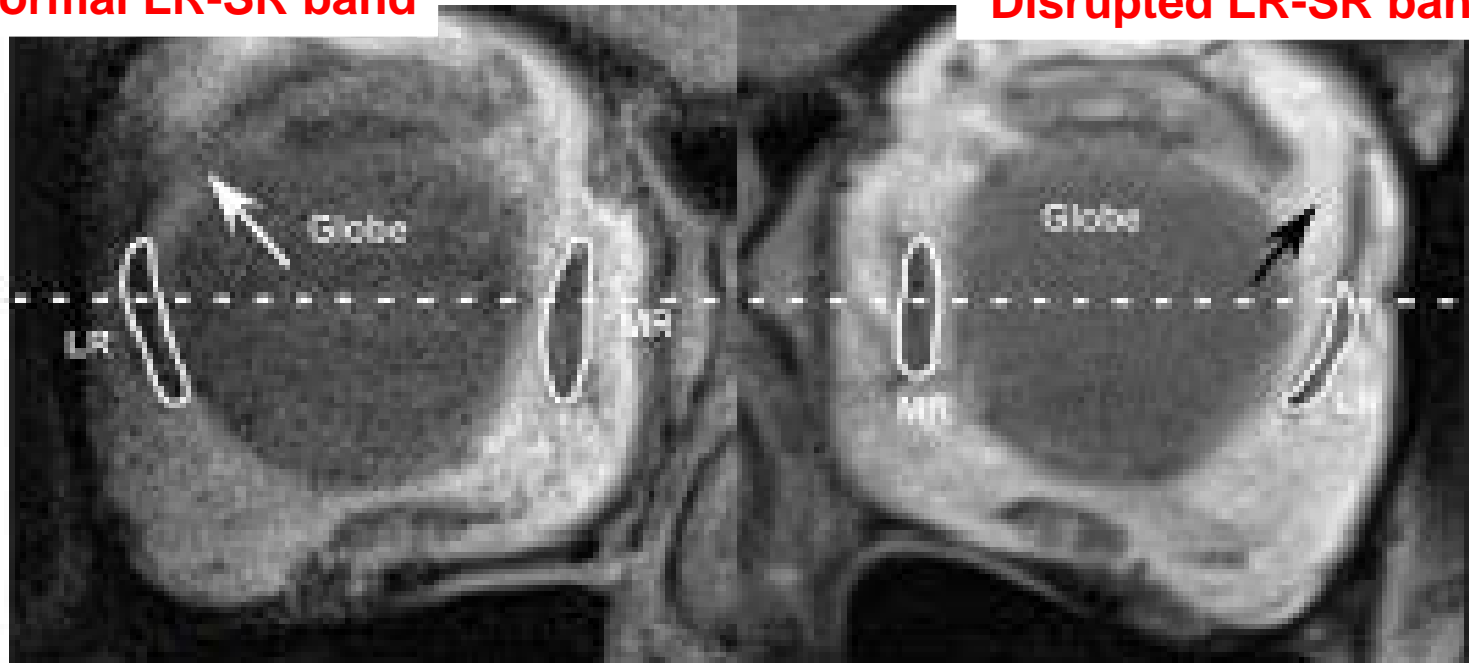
Coronal magnetic resonance imaging near the equator of the globe in an elderly patient with age-related divergence insufficiency esotropia shows an intact lateral rectus-superior rectus band in the right orbit (white arrow) with a normal lateral rectus pulley position and a dehiscenced lateral rectus-superior rectus band in the left orbit (black arrow) with an inferiorly displaced lateral rectus pulley. MR =
